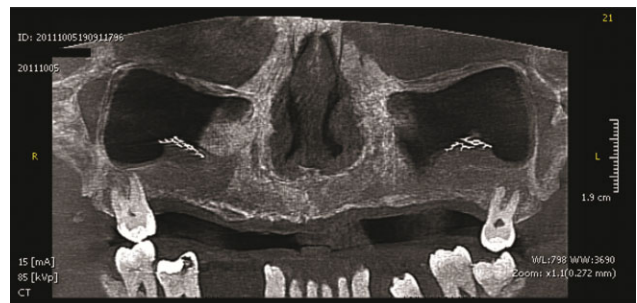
Reformatted panoramic view from the 6 months postoperative CBCT for the same patient as in Figure 8 showing new bone formation within the tented area.
